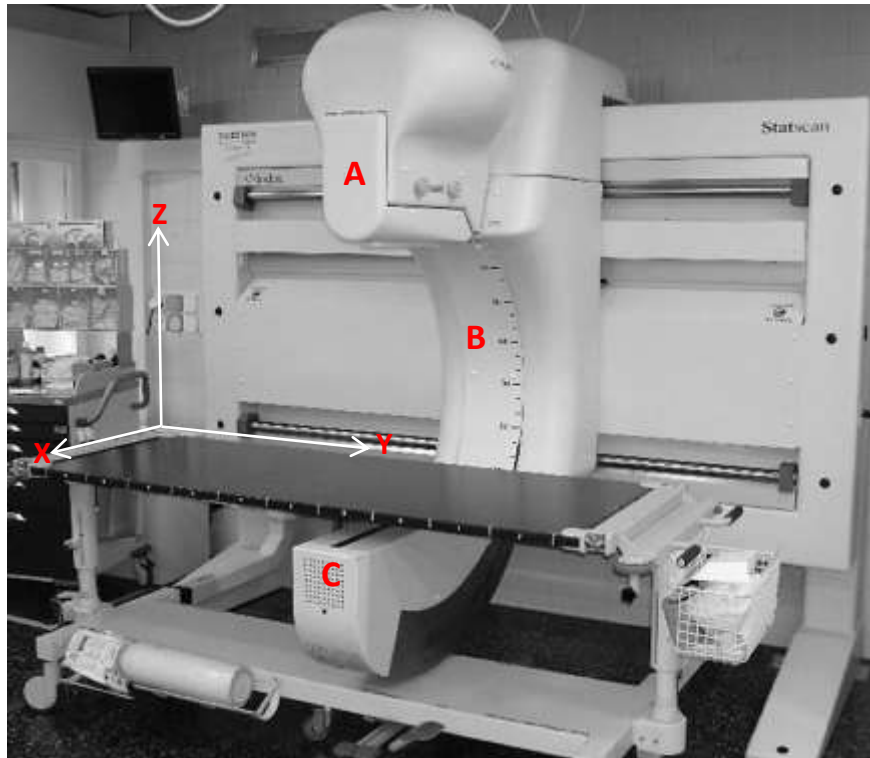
Lodox Statscan imaging system; A is the X-ray source, B is the C-arm and C houses X-ray detectors.
